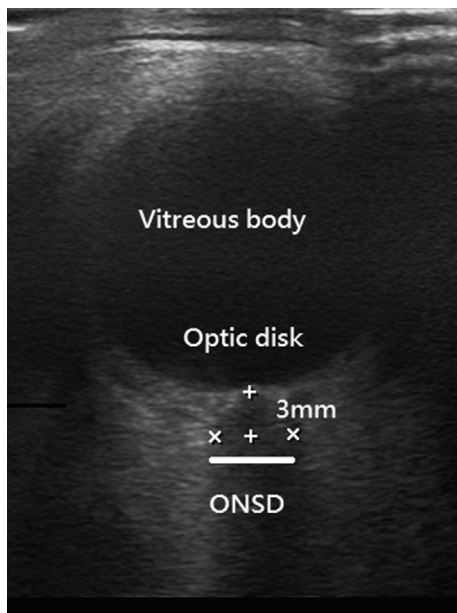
Representative ultrasound images from anterior transbulbar ultrasonography. ONSD is determined by measuring the diameter from the inner-edge to inner-edge of the optic nerve sheath at 3 mm behind the globe, using the optic disc as a reference point. (+..+ : 3 mm behind the globe; x..x : ONSD: optic nerve sheath diameter).
